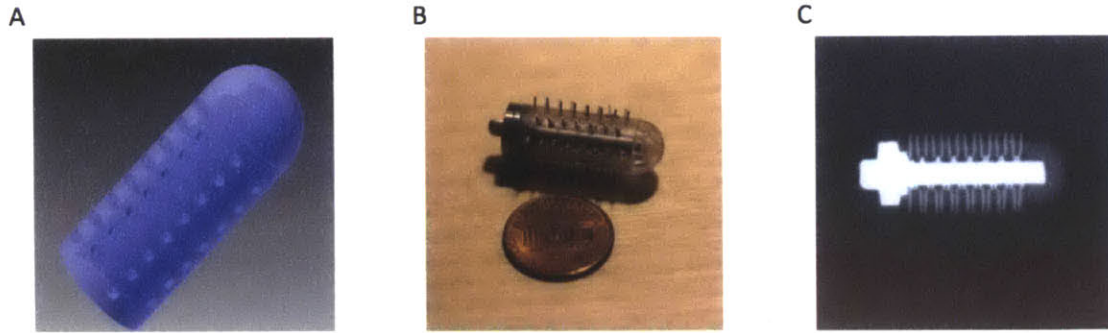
A cylindrical microneedle pill for the oral administration of biologic drugs. (A) Computer-aided design of the radial prototype housing used for *in vivo* safety evaluation. (B) Finished prototype used for *in vivo* safety showing the metal endcap and pin. (C) Radiography of the prototype in (B). Pill length 2cm, diameter 1cm, needle gauge – 25G.
